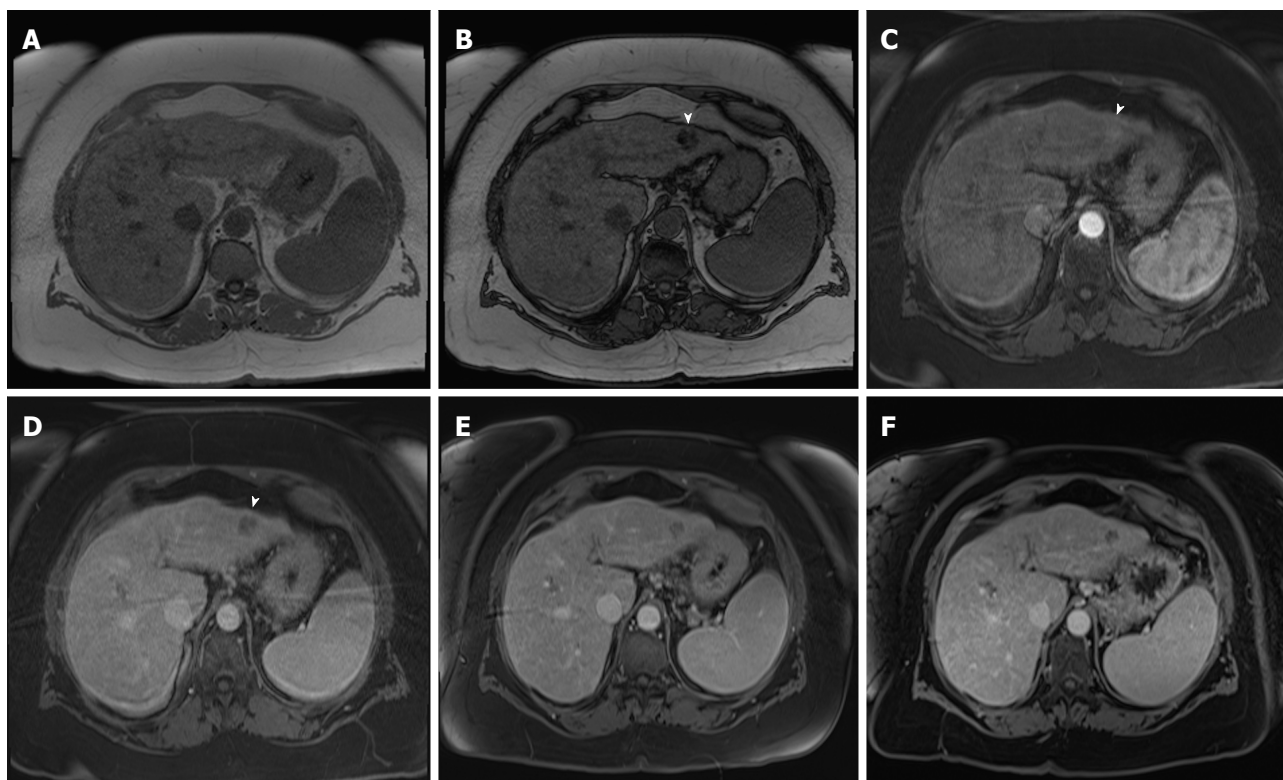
Slow growing, well-differentiated, fat-containing, small hepatocellular carcinoma. In-phase (A) and opposed-phase GRE T1 weighted images (B); Post-contrast fat-suppressed 3D-GRE T1-weighted images during the late hepatic (C) arterial and delayed phases (D). E, F: Post-contrast fat-suppressed 3D-GRE T1-weighted delayed images from prior examinations performed 1 and 2 years prior, respectively. The is a small left hepatic lobe nodule, which demonstrates drop of signal on the opposed-phase image (arrowhead, B) compared to the in-phase image (A), increased arterial enhancement (arrowhead, C), and delayed washout (arrowhead, D). The lesion does not demonstrate significant change in size from the immediate prior examination (E). However, when compared with a more remote examination (F), substantial interval growth can be appreciated consistent with a slow growing, well-differentiated, fat-containing, small HCC. HCC: Hepatocellular carcinoma; GRE: Gradient recalled echo.
